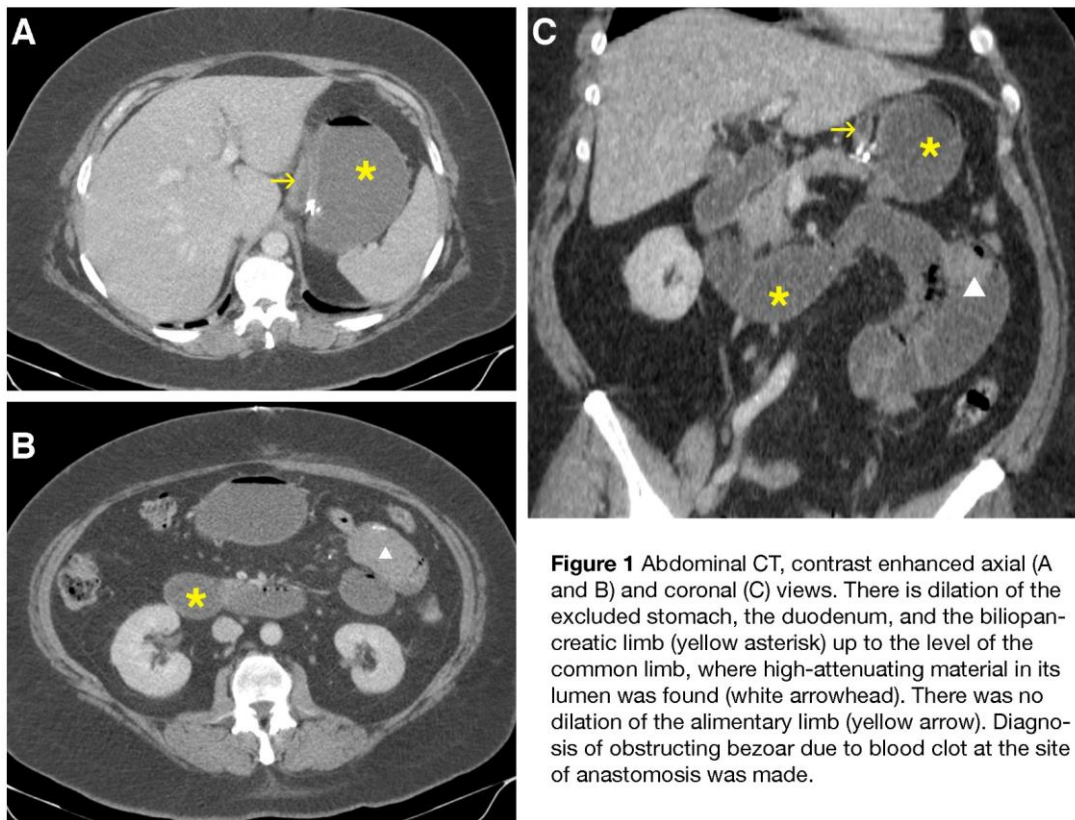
Abdominal CT, contrast enhanced axial (A and B) and coronal (C) views. There is dilation of the excluded stomach, the duodenum, and the biliopancreatic limb (yellow asterisk) up to the level of the common limb, where high-attenuating material in its lumen was found (white arrowhead). There was no dilation of the alimentary limb (yellow arrow). Diagnosis of obstructing bezoar due to blood clot at the site of anastomosis was made.
